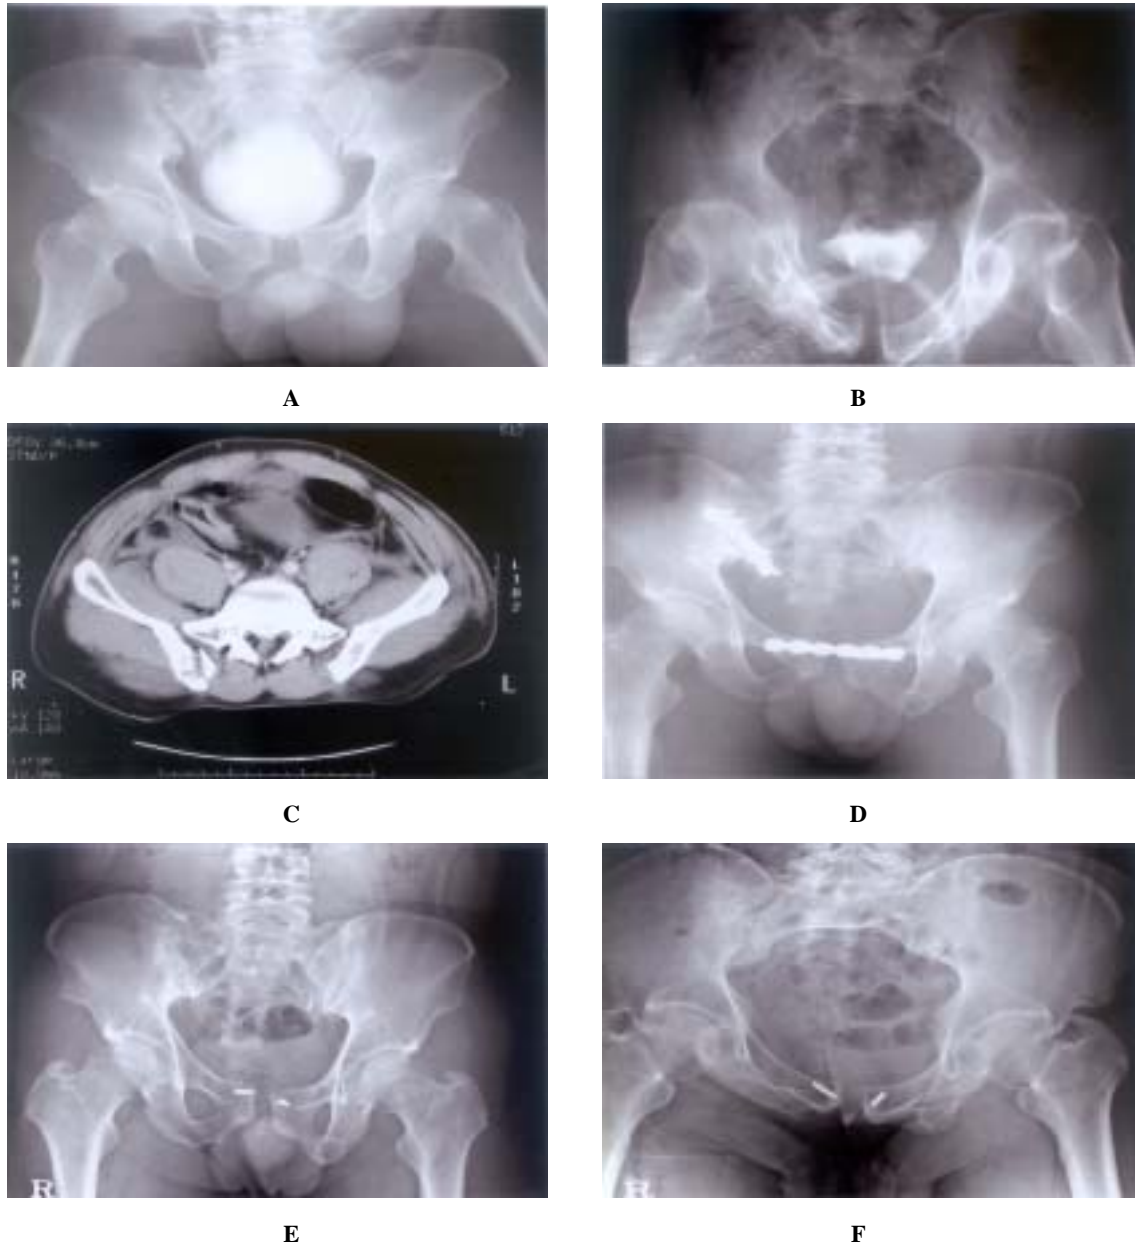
A 30-year-old male patient who was injured by traffic accident, he had a right SI joints fracture and dislocation and symphysis pubis separation. In simple pelvis AP (A) and inlet view (B), there were SI joint widening, symphysis pubis separation and left inferior ramus fracture. Computed tomography (C) shows ilium fracture and right SI joint widening. Reduction and internal fixation was done, pelvis AP (D). Post operation 24months, pelvis AP (E) and inlet (F) view show good reduction.
